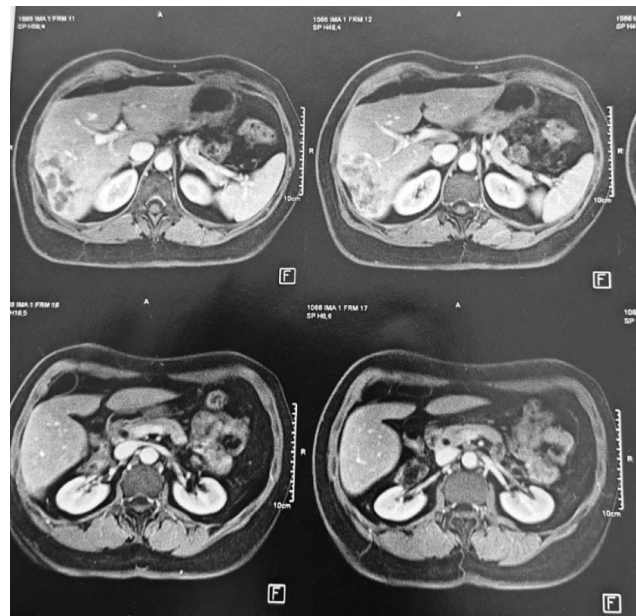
The computed tomography scan with the presence of liver lesions in segments VI and VII.
